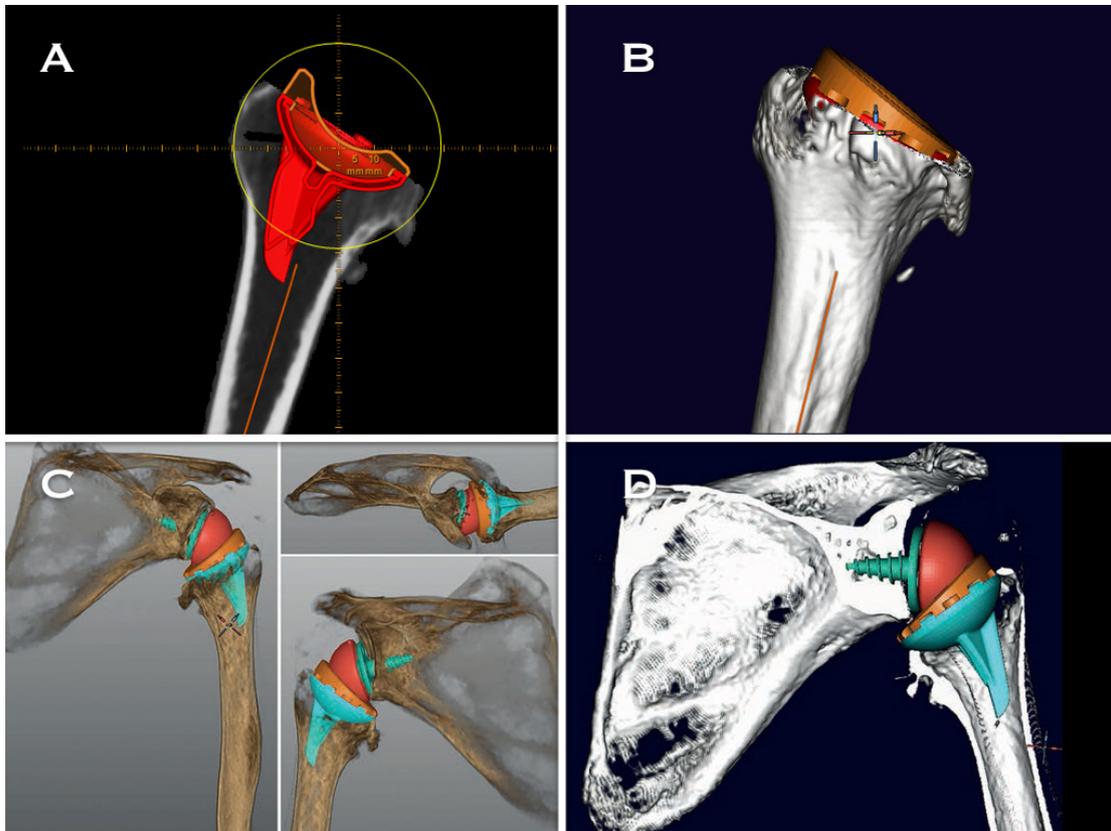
4A. X-ray in anteroposterior view of a right proximal humerus, in which the inlay design and the metaphyseal fixation of the Verso can be seen in the pre-op planification. Notice that the shell of the humeral component is flush with the humeral osteotomy, and that the tip of the humeral component does not reach the proximal third of the diaphysis.
